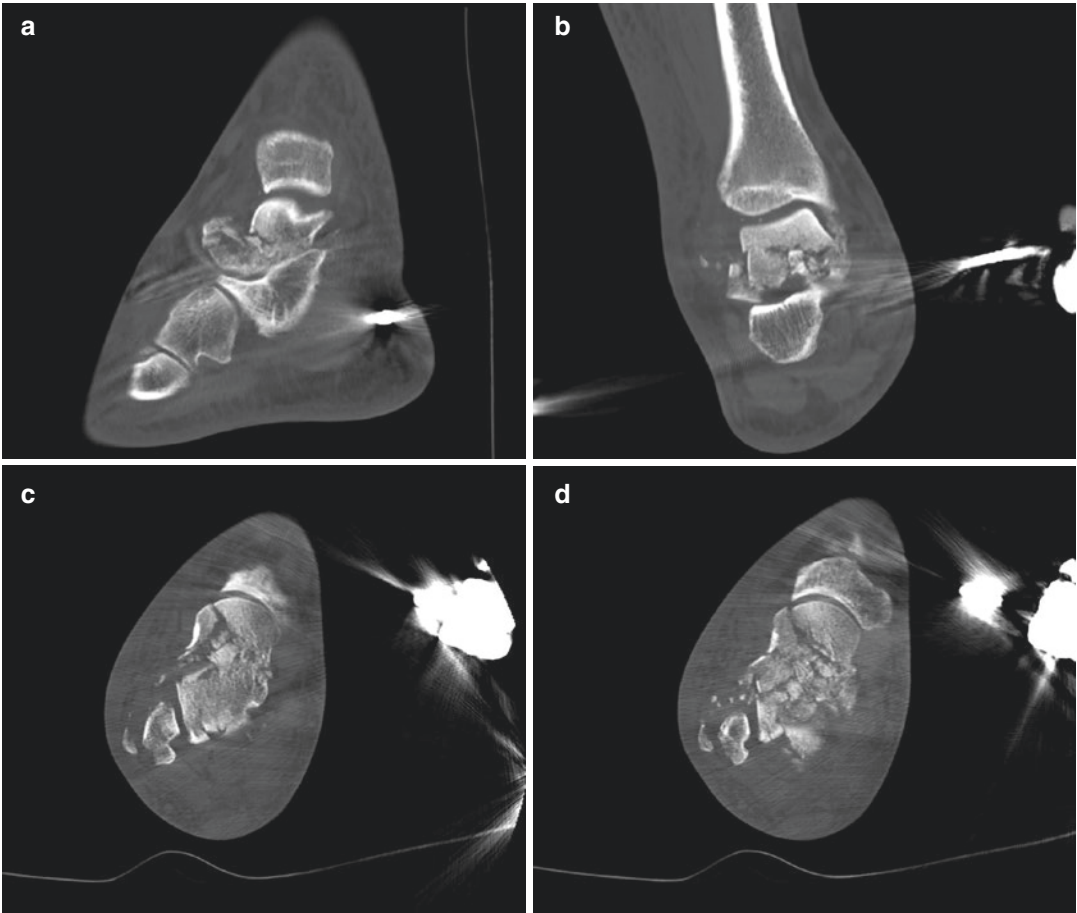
(a–d) Preoperative CT scans demonstrating marked dorsal and medial comminution with considerable involvement of the subtler surface best appreciated on coronal cut
